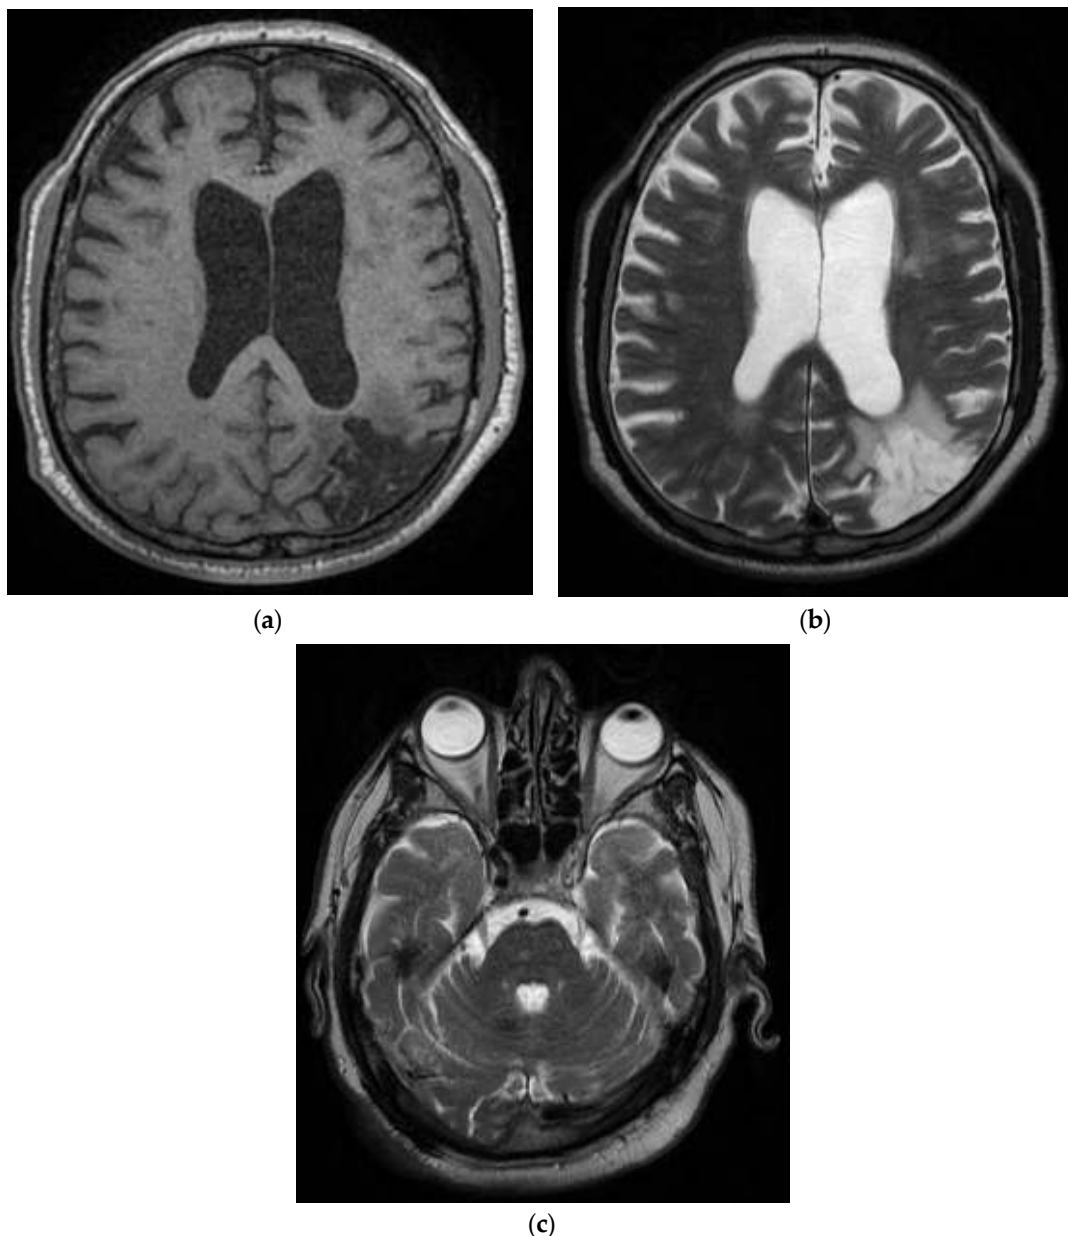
T1 and T2 MRI sequences in the Case 4 patient reveal left porencephalic–gliotic cortical–subcortical parietal–occipital, with a minor retractile effect on the left lateral ventricle; ischemic chronic softening on the left Sylvian territory and on the superficial territory at the border of the median cerebral artery–left posterior cerebral artery (a,b). The T2 MRI sequence shows the left internal carotid artery without a signal of circulatory flow in the intracranial segments (c); the rest of the big arteries located at the bases of the brain with no modifications of intraluminal signal that can be observed on the parenchymal sequences; occlusion of the left internal carotid artery (c).
